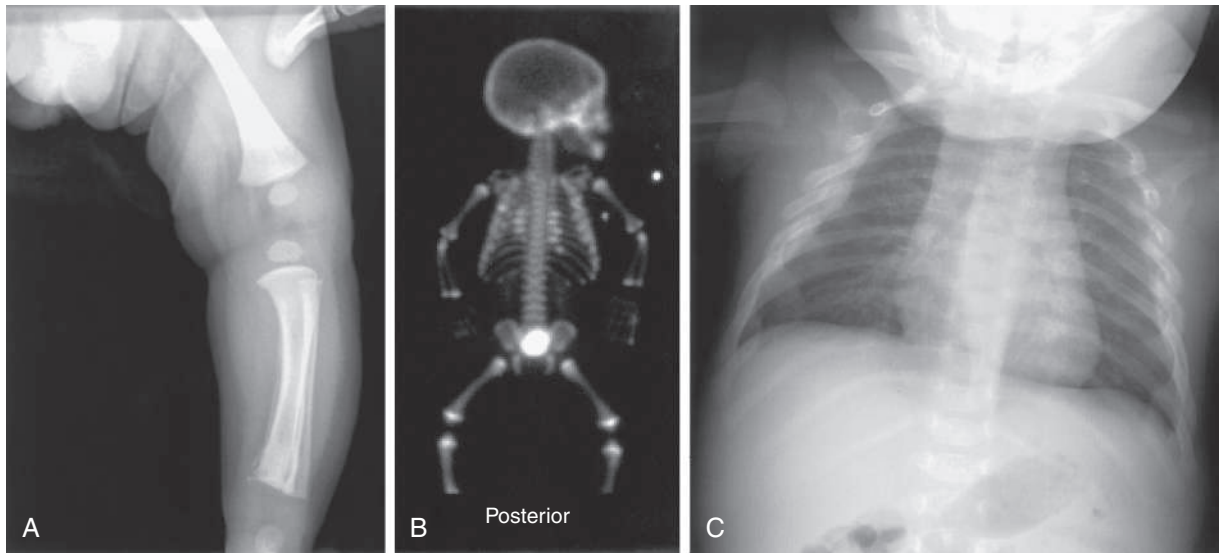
A, Metaphyseal fracture of the distal tibia in a 3-month-old infant admitted to the hospital with severe head injury. There is also periosteal new bone formation of the tibia, perhaps from previous injury. B, Bone scan of the same infant. The initial chest x-ray showed a single fracture of the right posterior fourth rib. A radionuclide bone scan performed 2 days later revealed multiple previously unrecognized fractures of the posterior and lateral ribs. C, Follow-up radiograph 2 weeks later showed multiple healing rib fractures. This pattern of fractures is highly specific for child abuse. The mechanism of these injuries is usually violent squeezing of the chest.
